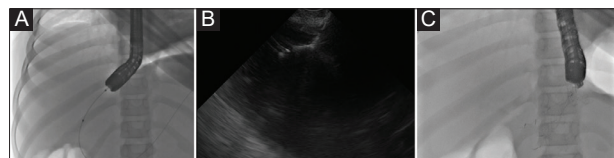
(A) Endoscopic ultrasound (EUS)-guided drainage using the forward-viewing echoendoscope: a guidewire was coiled inside the walled-off necrosis and the access site was dilated using 4-mm biliary balloon dilator. A 14-mm wide fully covered bi-flanged self-expanding metallic stent was deployed under EUS (B) and fluoroscopic (C) guidance
